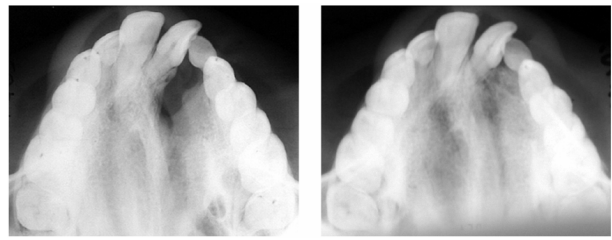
Preoperative and postoperative occlusal radiographs of the patient.
